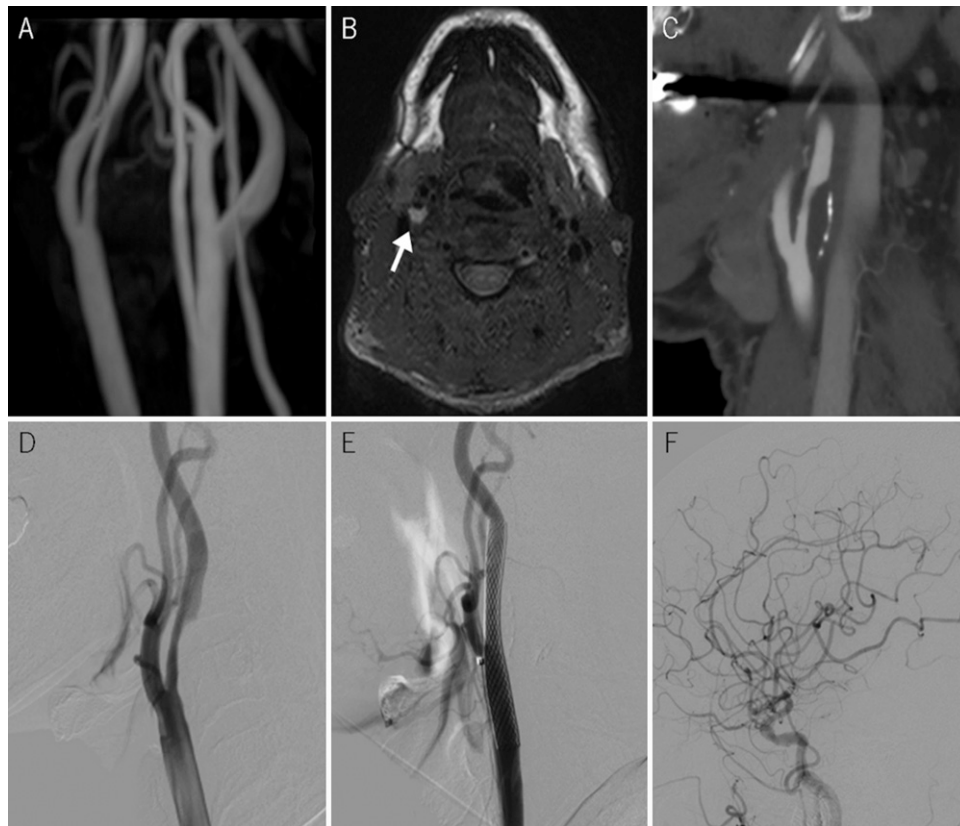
A: Neck MRA shows right cervical ICA stenosis B: Black-blood T1-weighted magnetic resonance imaging shows a high-intensity signal in the plaque (*arrow*). C: Neck CTA shows 70% stenosis according to the North American Symptomatic Carotid Endarterectomy Trial criteria. D: Preoperative digital subtraction angiography (DSA), lateral view, showing severe stenosis in the right ICA. Postoperative DSA, lateral views, shows a dilated stenotic lesion after CAS (E) and no intracranial abnormalities (F).
